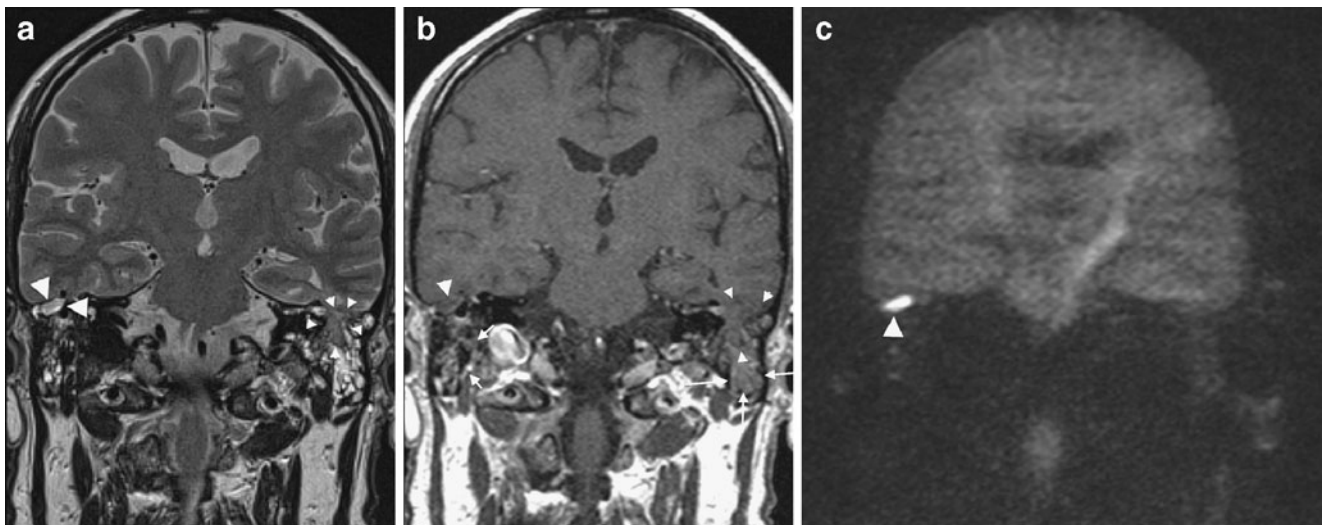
A 25-year-old female with a history of cholesteatoma surgery on the left side. The clinical examination was unremarkable. a Coronal 2-mm-thick TSE T2-weighted MR image at the level of the mastoid. On the left side, there seems to be protrusion of a part of the temporal lobe through a defect in the tegmen (*small arrowheads*) into the mastoid. On the right side, an oval structure with intermediate signal intensity is seen beneath the tegmen (*large arrowheads*). b Coronal 2-mm-thick delayed post-gadolinium SE T1-weighted MR image (same level as a). On the left side, the protruding temporal lobe can be seen as a lesion which is isointense to brain (*small arrowheads*) and which is surrounded by enhancing inflammatory tissue with a slightly higher signal intensity (*long arrows*). On the right side, there
